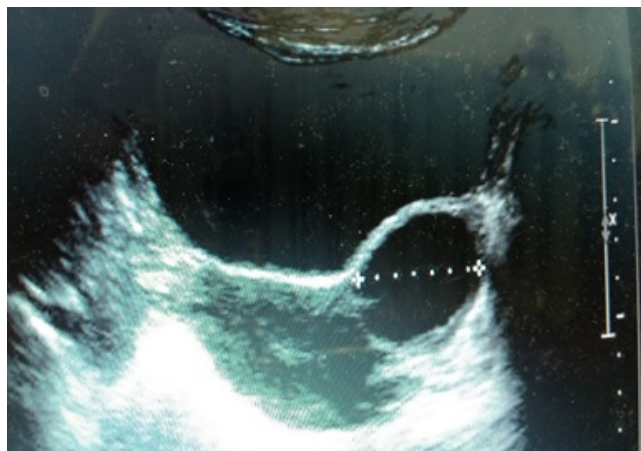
Clinical examination there is mild lower abdominal tenderness by ultrasound.
